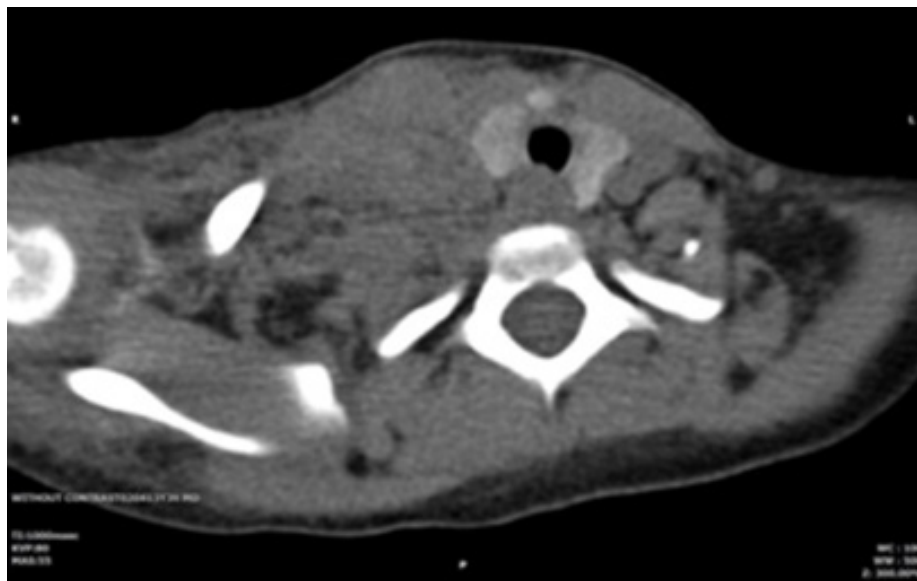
Right-sided neck hematoma on cervical CT scan of the 9-year-old patient with ESRD following permcath insertion
